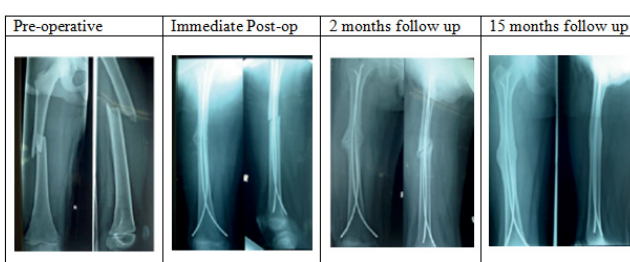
Radiographs of Femur TENS.
